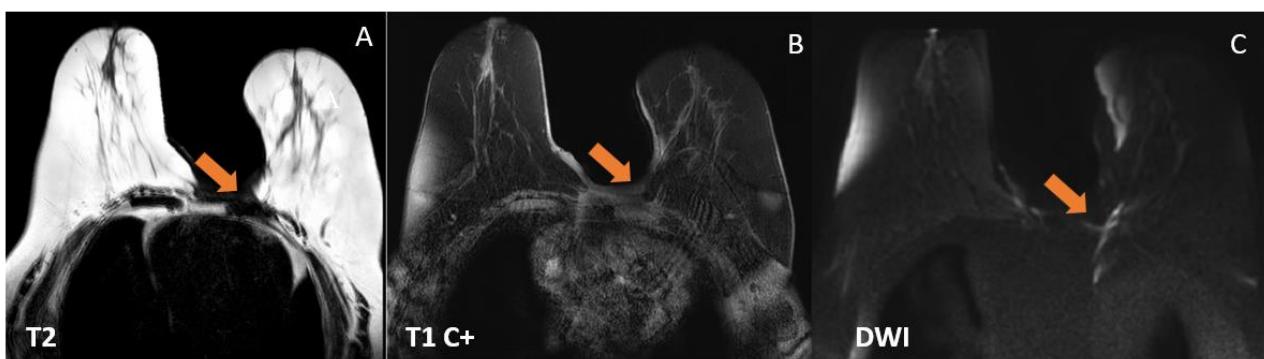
axial slices of a breast MRI revealing a regression of the tissular infiltration at the lumpectomy site
